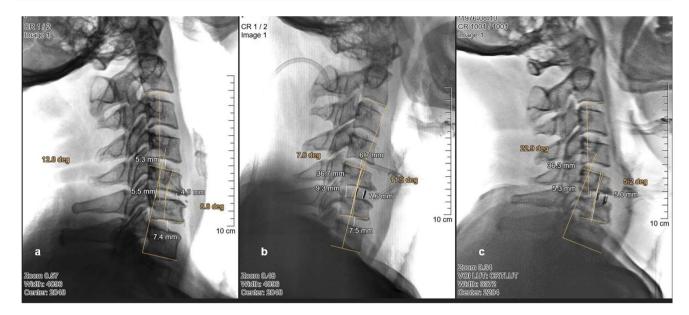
Showing a 32-year-old male patient with C56 collapsed disc space with radiculopathy. a Pre-operative radiographs show a collapsed and kyphotic C56 disc space. b The immediate postop radiograph with satisfactory cage placement and restoration of disc height.
